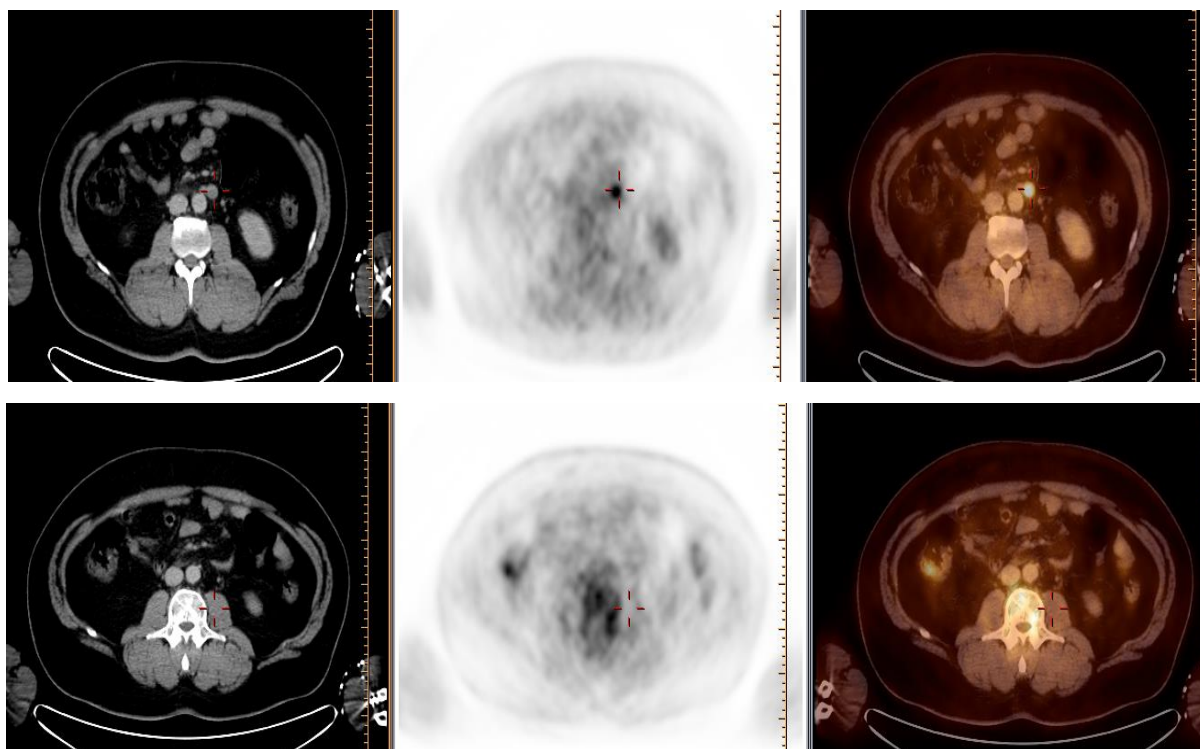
25 year-old male patient with Seminomatous testicular cancer (a) showed metastatic left para-aortic lymph node, with SUVmax~7.5. (b) Follow up PET/CT after 3 months of chemotherapy showed CMR.
